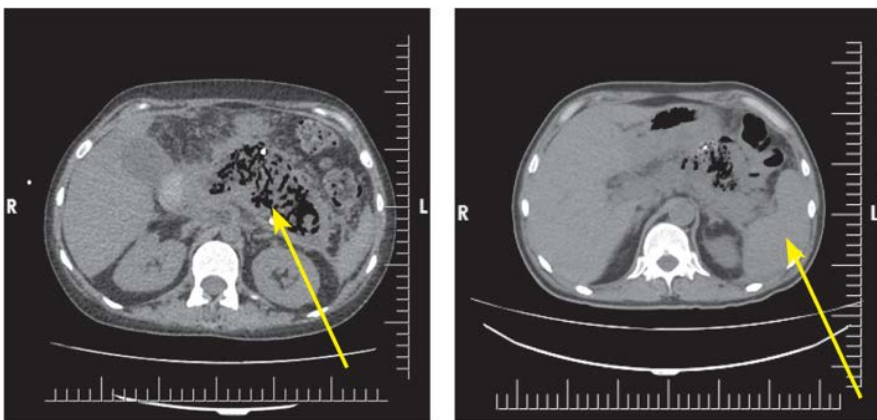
Computed tomography of the abdominal organs
